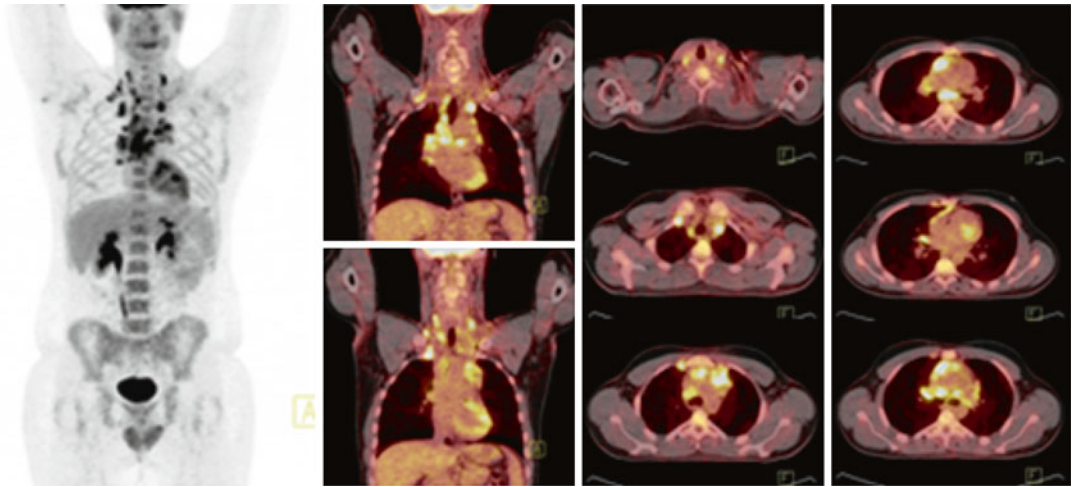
Initial staging PET/CT: hypermetabolic lymph nodes at the supraclavicular area; at the paratracheal, prevascular, precarinal, and infracarinal space; at the right pulmonary hilum; and along the right internal mammary vessels (SUVmax 11)
